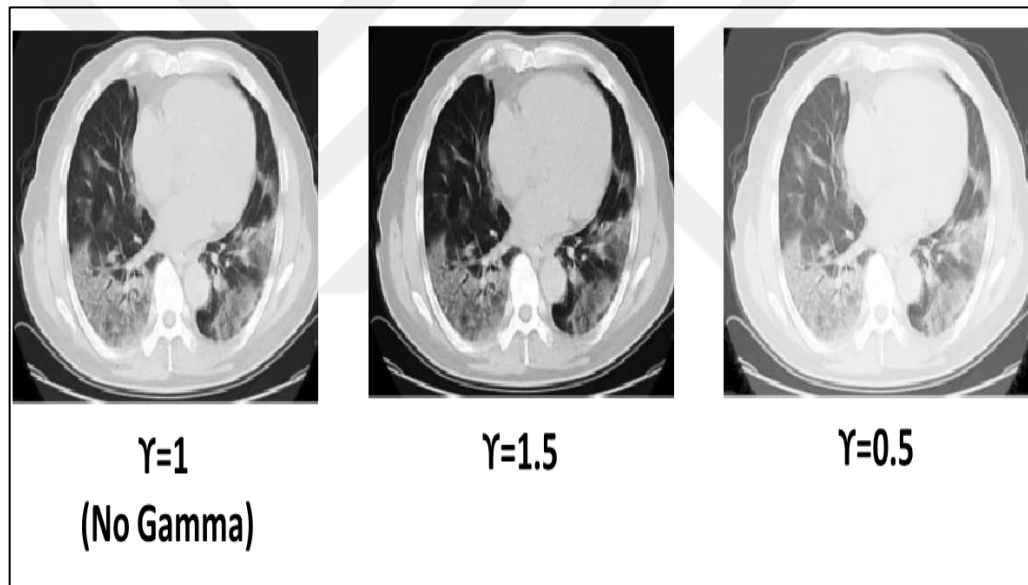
COVID CT images with different values of gamma correction.
